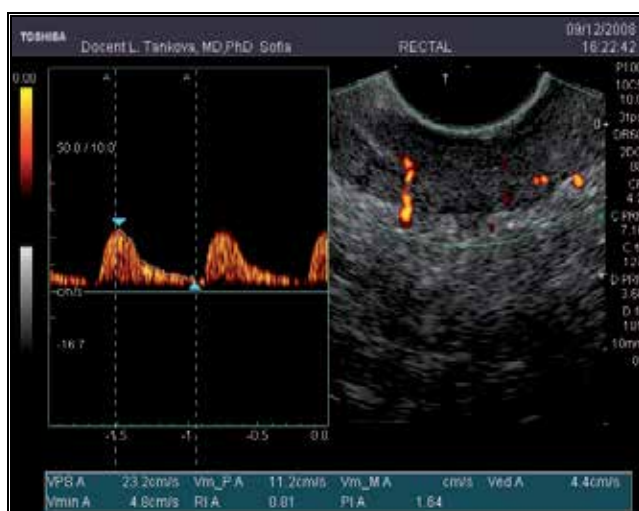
Power Doppler endosonography of rectal cancer with poor vascularisation (high RI - 0.81)
